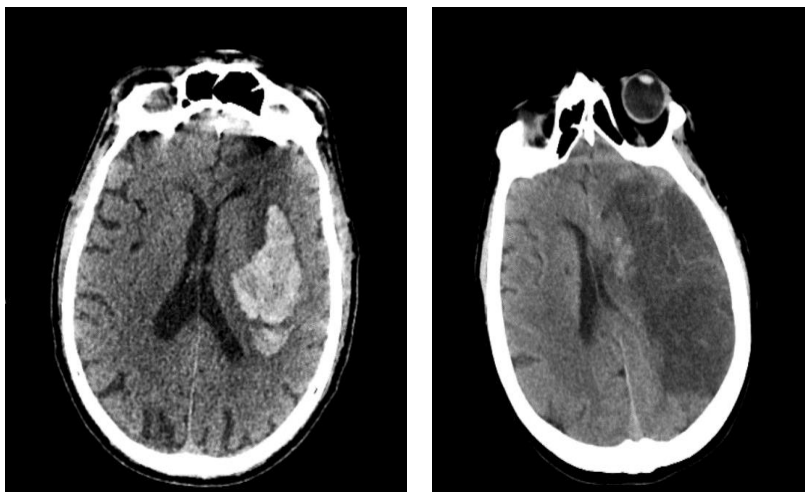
In the left aspect there is an image showing a cerebral CT-scan of an intra parenchymatous hematoma in contrast with the right aspect where it shows an ischaemic stroke.
